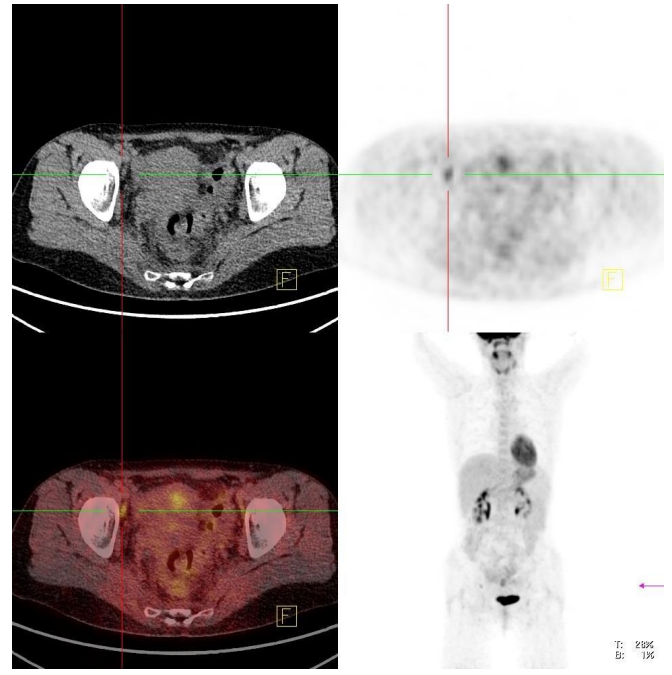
FDG PET/CT scan (axial CT, PET and fusion cross sections, as well as MIP) of a patient (34 years), showing an increased glucose metabolism in the uterus (pathologically confirmed recurrence of the cancer) and in obturator and parailiac lymph nodes (secondary deposits).
